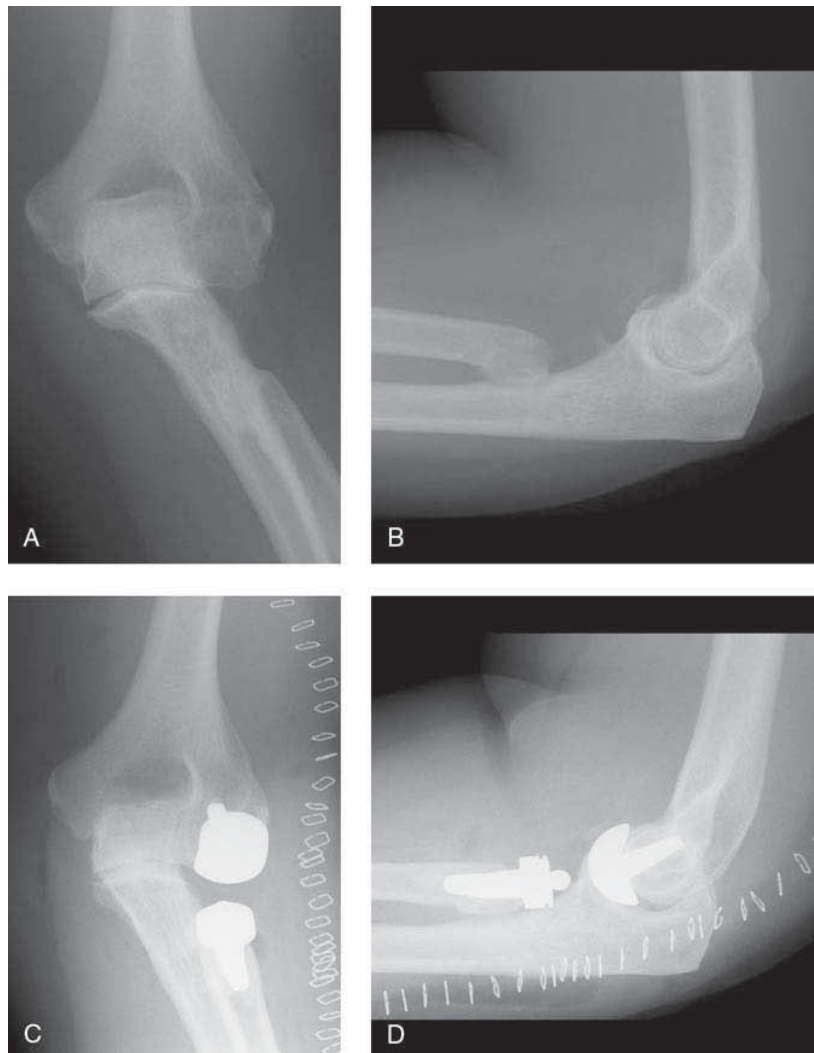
Radial head reconstruction with replacement arthroplasty. AP (A) and lateral (B) radiographs of the elbow of a 48-year-old man with pain, stiffness, and persistent clicking 6 months after open reduction and internal fixation of an elbow fracture-dislocation. The hardware had failed. AP (C) and lateral (D) radiographs 6 months after open capsular release and radial head replacement with a modular implant. The patient had no pain and nearly full range of motion.
